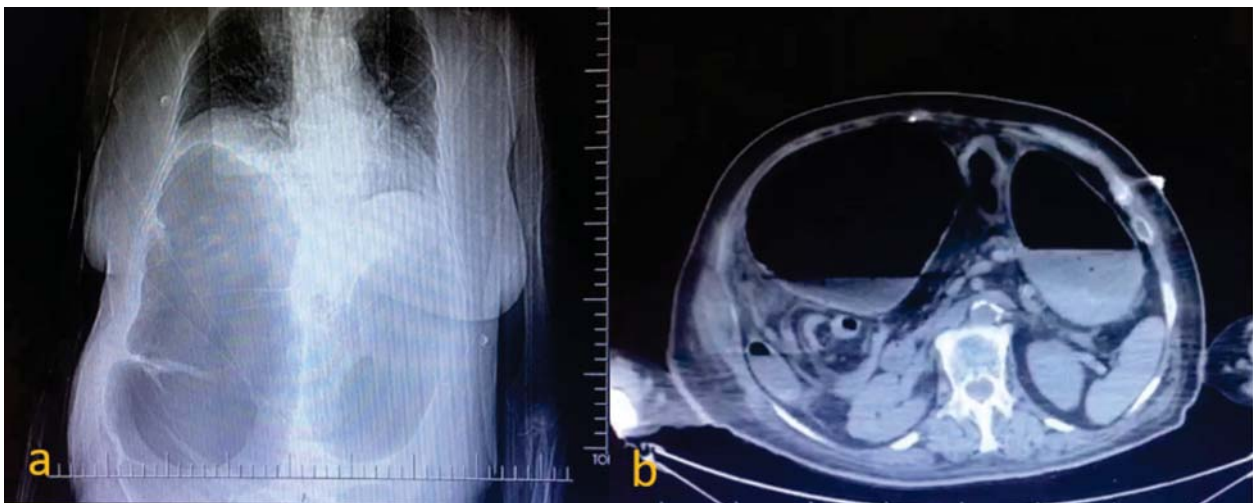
a) Abdomen X ray shows caecum in the lower left quadrant and enlarged colon segments on right. b) contrast enhanced-CT revealed enlarged intestinal loops with air-fluid levels
